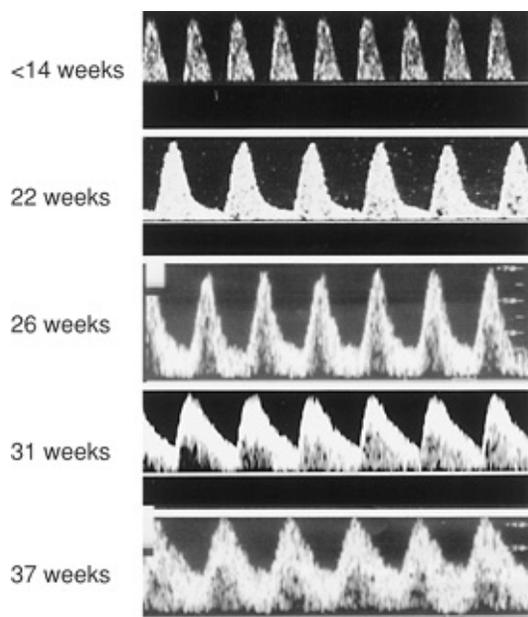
Doppler FVW profiles in the umbilical artery across normal gestation. Note the progressive increase in end-diastolic flow.
